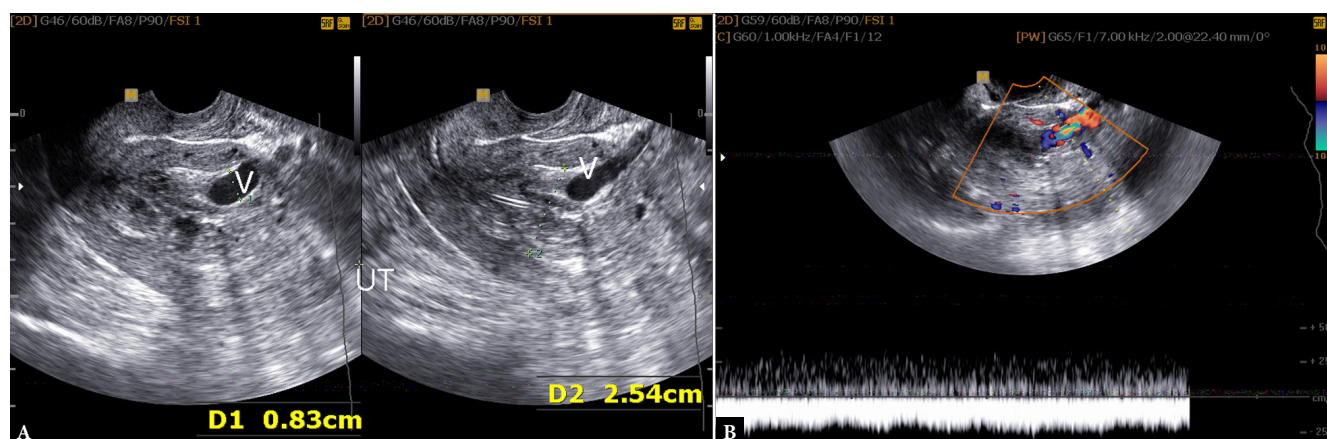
Transvaginal CD sonography showing intrauterine venous varix (V) with normal venous wall and phasic venous flow inside
